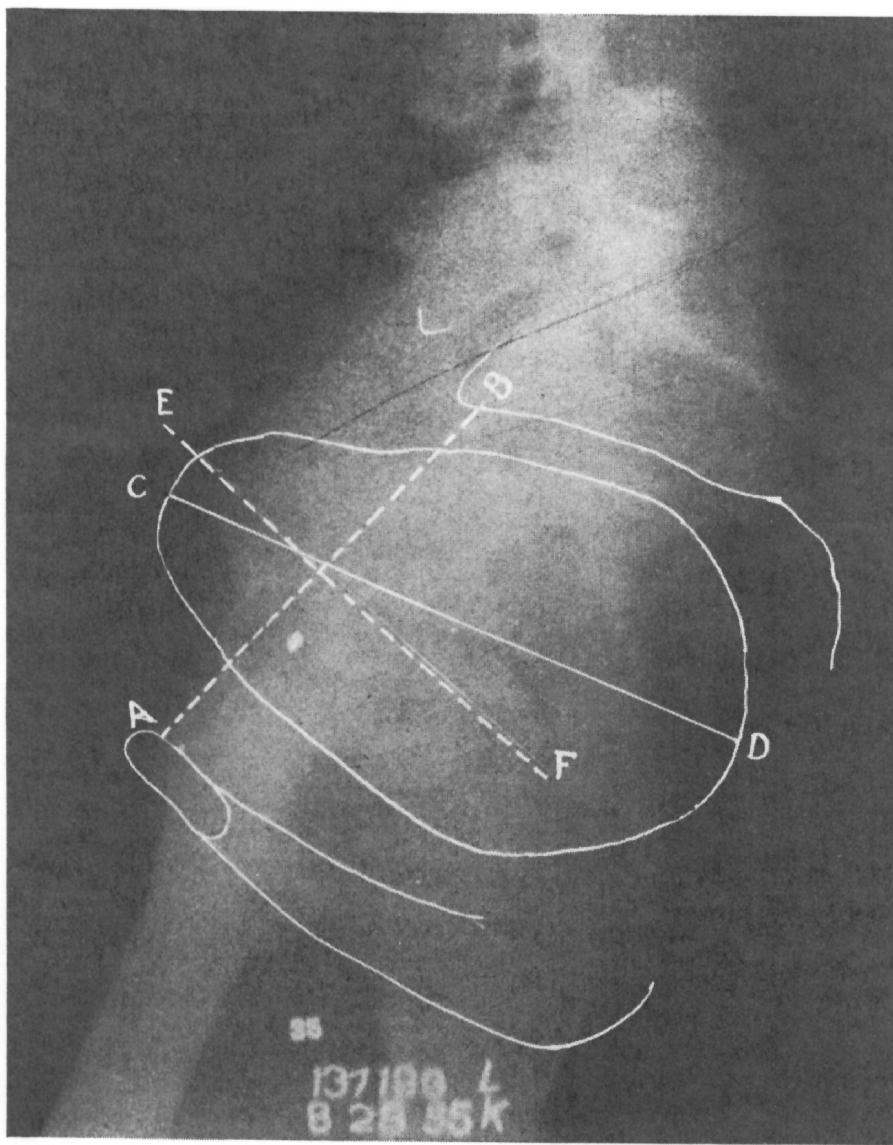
Lateral roentgenogram in labor. A, B., First plane of inlet and true conjugate diameter. C, D., Long axis of fetal head. E, F., Perpendicular to inlet through midpoint of true conjugate diameter. Engagement has occurred. Note that C, D, is parallel to sacrum and behind E, F. In this case, engagement occurred from a slight anterior parietal position as in Fig. 4.
